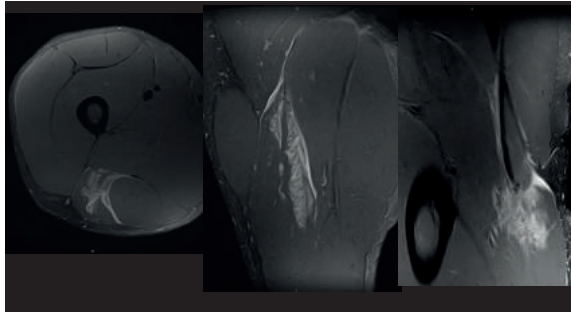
(Case #4). MTJ strain of the central tendon of the long head of the biceps femoris muscle. As MRI signs, we find interstitial oedema, tendinous consecutive disruptions, significant intermuscular fluid/haemorrhage, and loss of tension in the biceps tendon.
